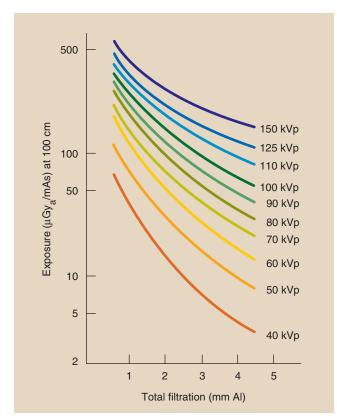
Nomogram for estimating the intensity of x-ray beams. From the position on the x-axis corresponding to the filtration of the imaging system, draw a vertical line until it intersects with the appropriate voltage (kVp). A horizontal line from that point will intersect the y-axis at the approximate x-ray intensity for the imaging system. (Courtesy Edward McCullough, University of Wisconsin.)
